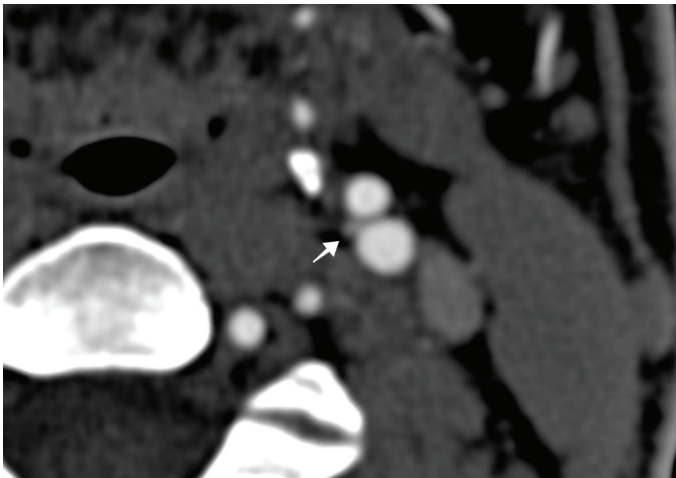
Axial CT image. CB in the left carotid bifurcation with indistinguishable borders from internal and external carotid arteries (arrow).
